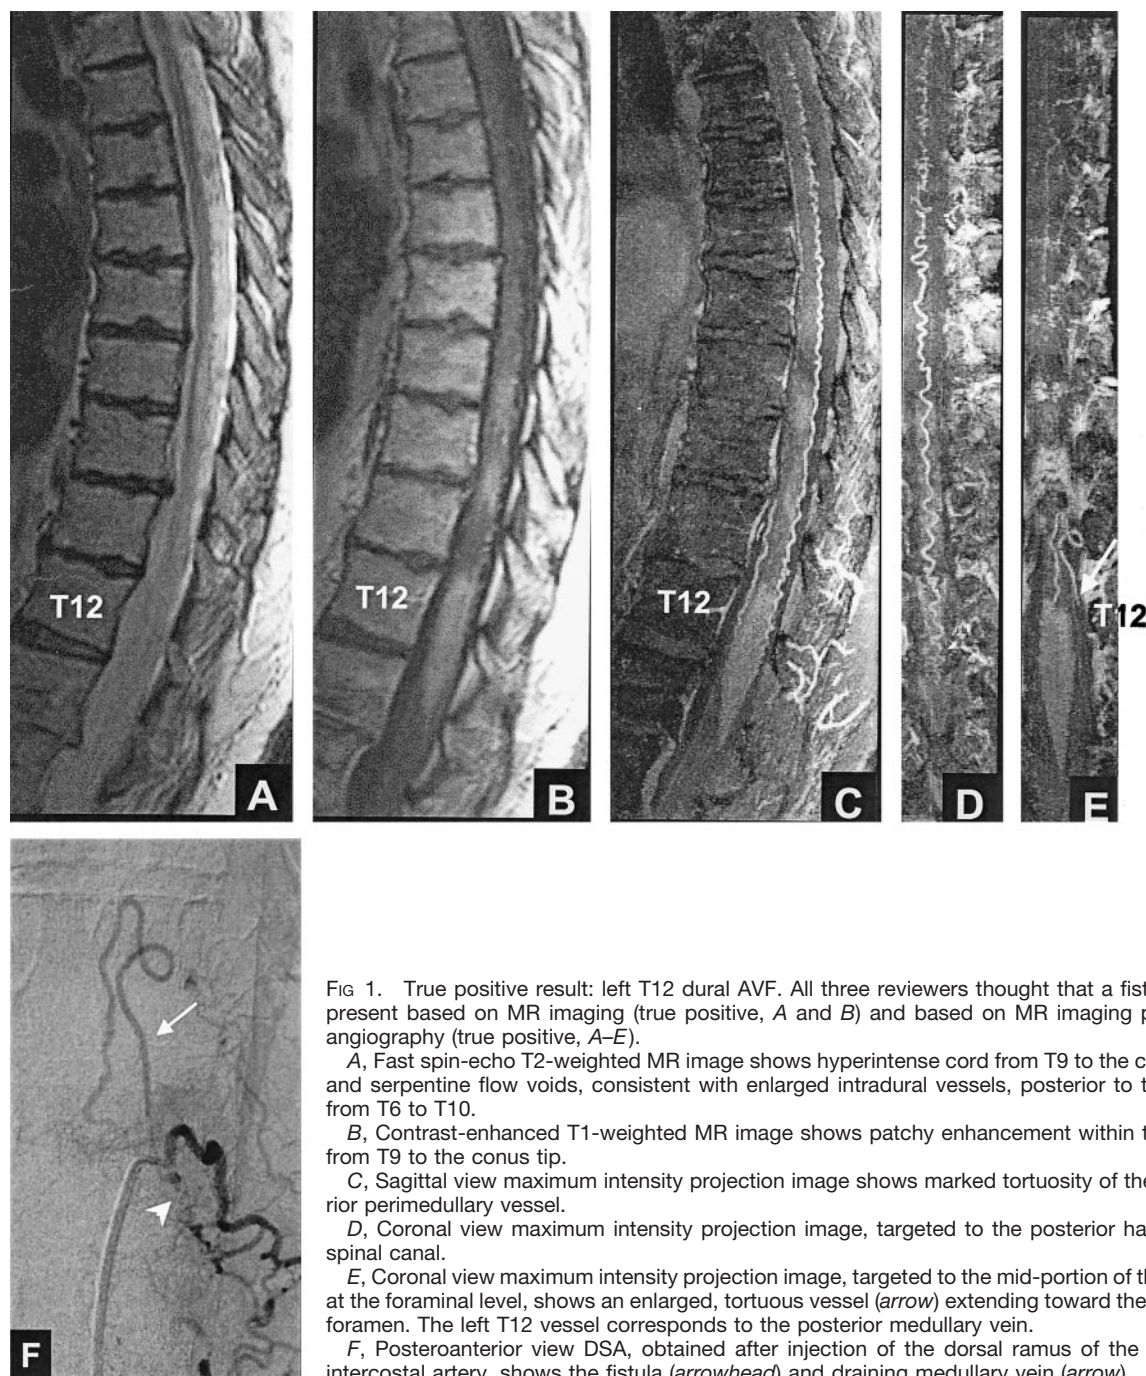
True positive result: left T12 dural AVF. All three reviewers thought that a fistula was present based on MR imaging (true positive, A and B) and based on MR imaging plus MR angiography (true positive, A–E).
